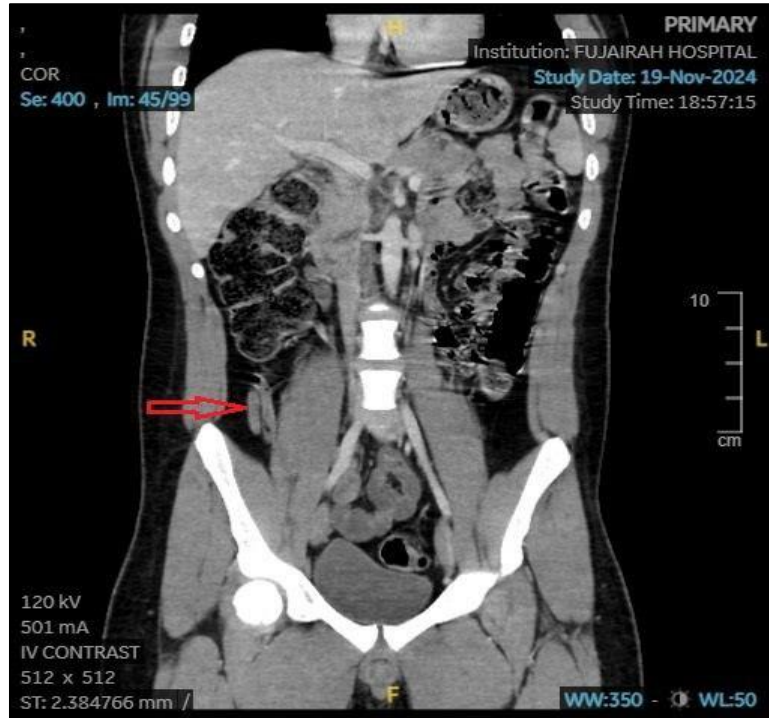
Coronal Contrast-Enhanced CT of the Abdomen shwoing normal appendix
